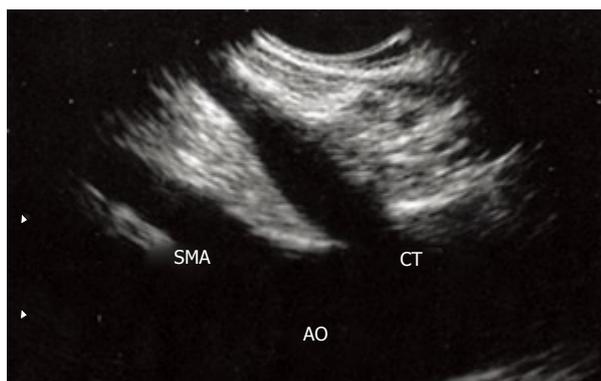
Endoscopic ultrasonography view of the aorta (AO), celiac trunk (CT), and superior mesenteric artery (SMA).
